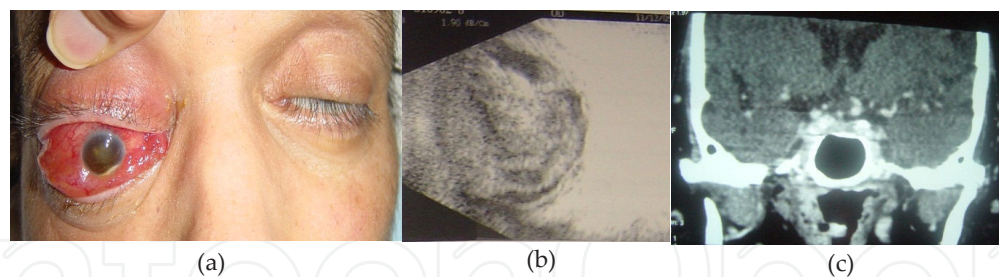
External photograph of a diabetic patient who presented with loss of vision and painful ophthalmoplegia of his right eye along with fever and mental status changes (a). He was found to have severe panophthalmitis of his right eye and ultrasonography revealed endophthalmitis (b). Computed tomography (coronal view) of his brain revealed evidence of septic emboli (c). Patient was treated with systemic antibiotics and right eye evisceration.
